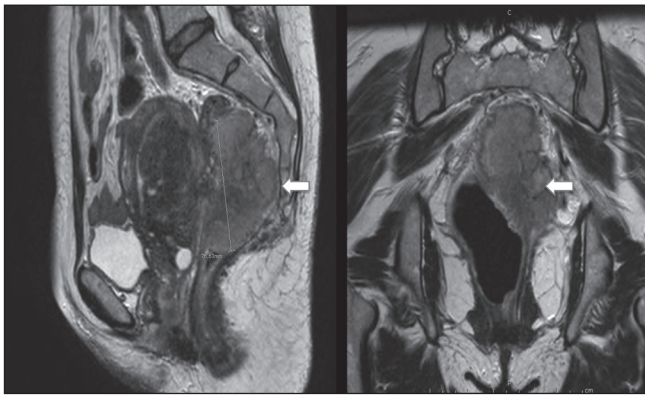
Pelvic magnetic resonance imaging.
